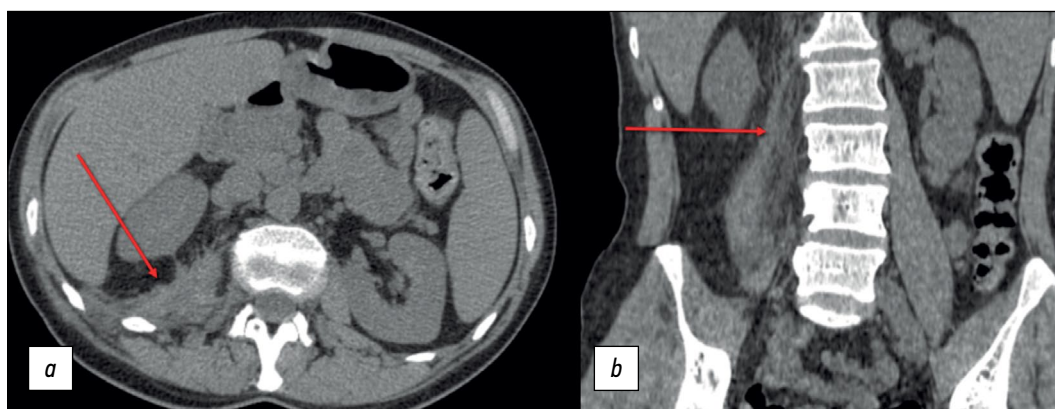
Lumbar spine MRI: (a) soft tissue mode, axial plane, and (b) soft tissue mode, coronal plane. The arrows indicate the right psoas muscle abscess.
